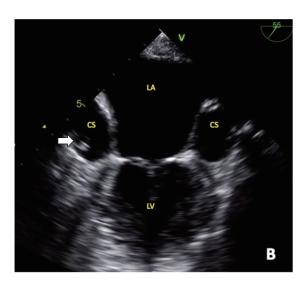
Transesophageal echocardiogram with the catheter noted within the coronary sinus. White arrow demonstrates catheter. LA: Left Atrium, CS: Coronary Sinus, LV: Left Ventricle.
